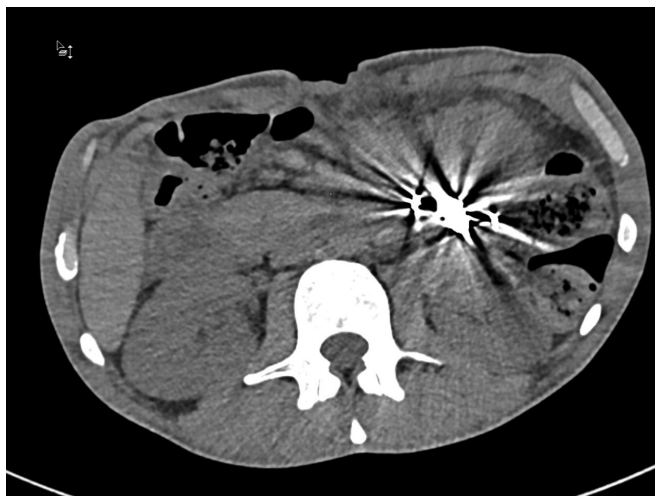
Computed tomography scan of the abdomen of a 42-year-old man, showing material at the gastric endoluminal site causing beam-hardening artifacts related to the presence of ingested objects.
